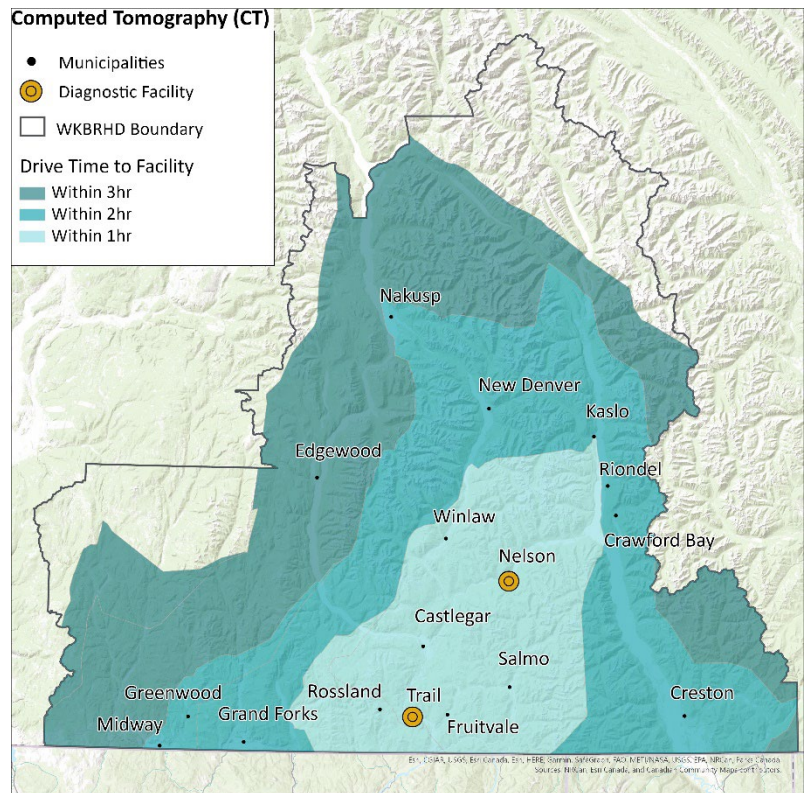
Service area distances to computed tomography (CT) diagnostic facilities in the WKBRHD
